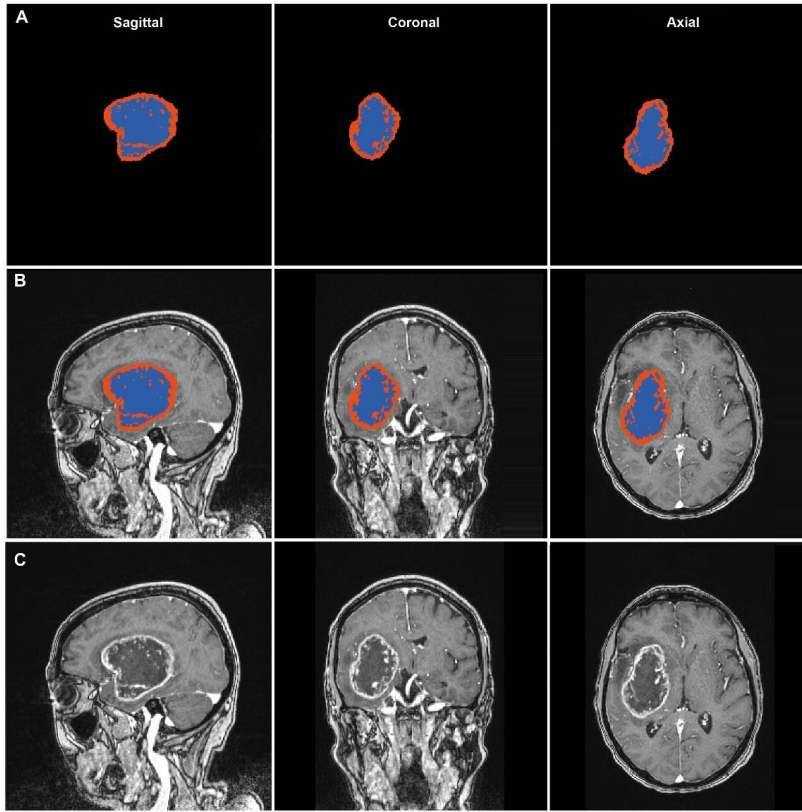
Manual segmentation of tumor volumes using the software BrainVoyager QX. The segmented contrast-enhancing compartment is marked in red, and the non-contrast-enhancing compartment (i.e. necrosis) in blue. Total tumor volume was the combined volume of both compartments. Panel A The segmented tumor area in all 3D planes. Panel B Segmented areas together with the original image. Panel C Original T1-weighted contrast-enhancing images. Picture courtesy of Anne Line Stensj en
